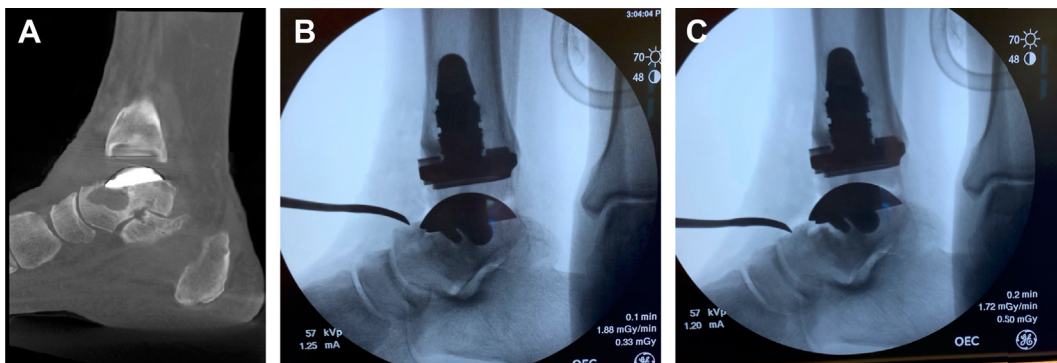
(A) Sagittal CT imaging demonstrating periprosthetic bone cyst within the talar neck 7 years following TAA. (B and C) Intraoperative fluoroscopy demonstrating subsequent periprosthetic fracture of the talus and implant loosening.
